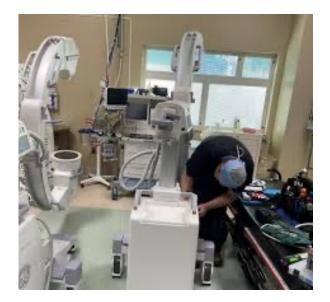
routine X-ray machine maintenance
